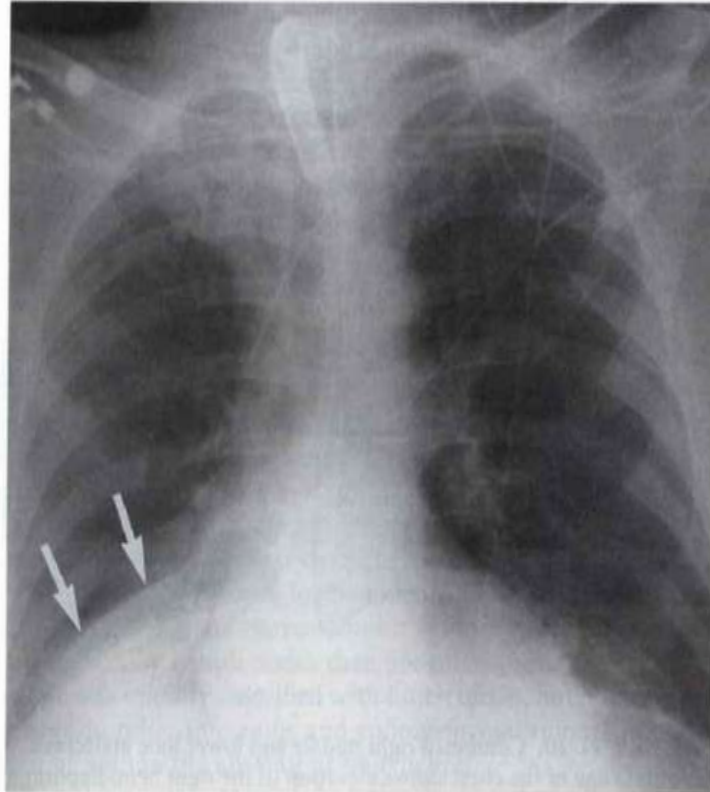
Bilateral lower lobe atelectasis. AP supine chest radiograph of a 61-year-old man shows partial loss of the contours of the hemidiaphragms bilaterally, abnormal opacification of the lung bases, and inferior displacement of the minor fissure (*arrows*).
